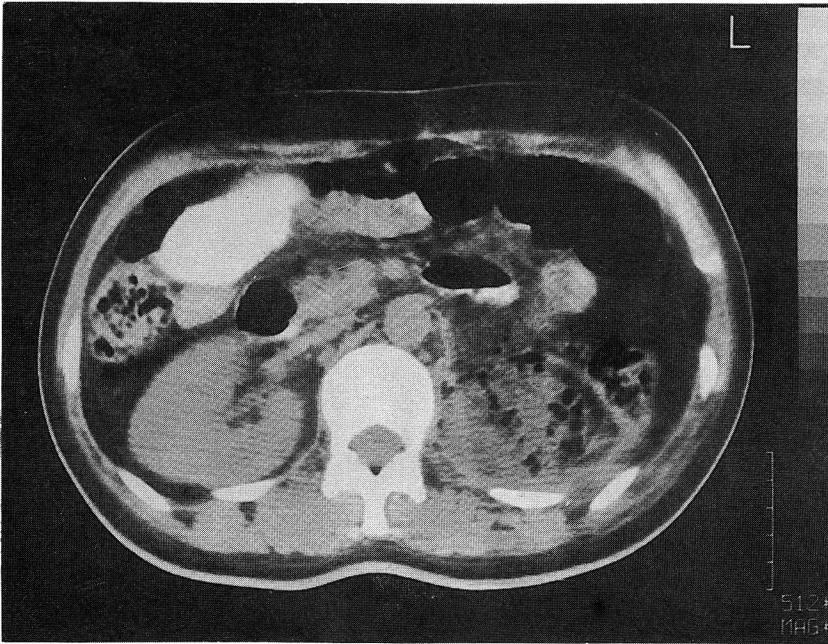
CT scan through the mid-abdomen shows abscess with multiple air bubbles in left side renal fossa.
